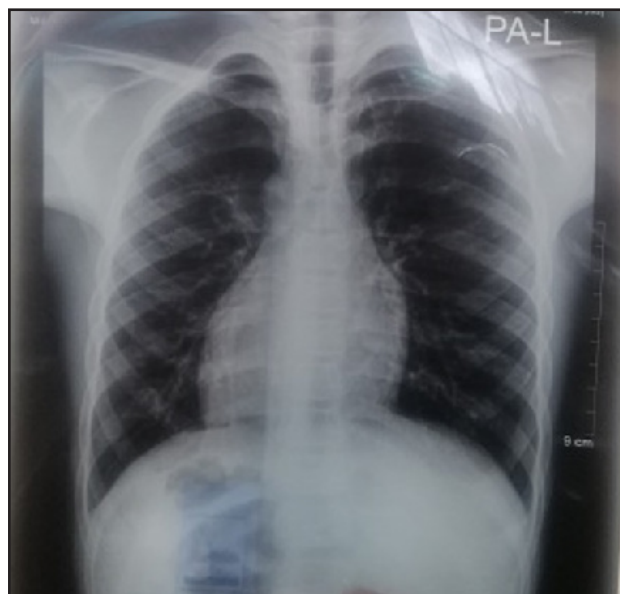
Chest X-ray showing apex of cardiac silhouette towards right side (Dextrocardia) with fundic gas shadow in right hypochondriac region.
